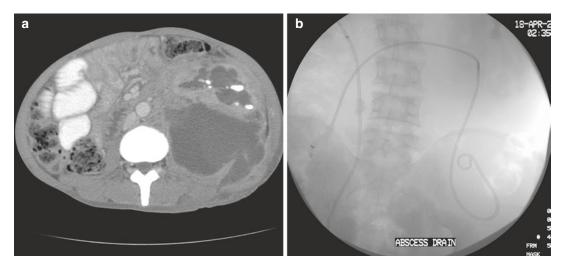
(a) Contrast-enhanced CT of the abdomen in a patient with sepsis demonstrates a large left retroperitoneal abscess. (b) Spot fluoroscopic image following
